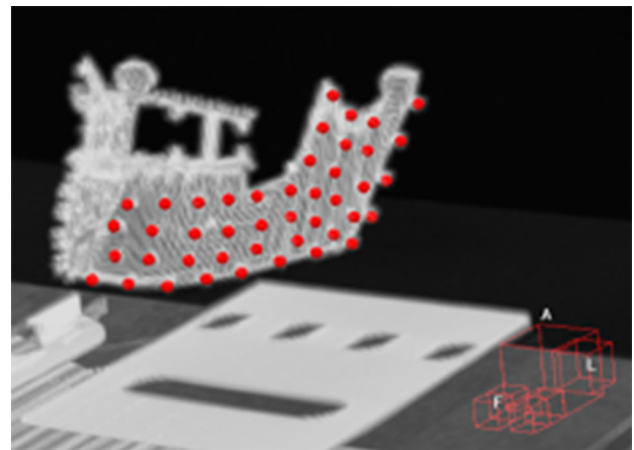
The 45 points at the affected side of the mandible that are used to calculate the TRE, shown on the CT scan
